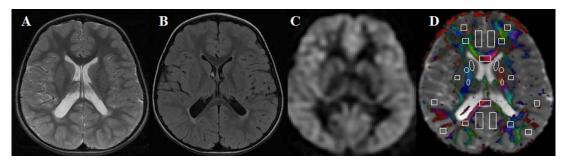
A. T₂ weighted, B, T2 FLAIR images show minimal hyper intensity in the periventricular regions. C. CBF map of a CP child with spastic diplegia. D. showing the coregistered map of CBF with DTI metrics and region of interest placed in different brain regions at the level of third ventricle
